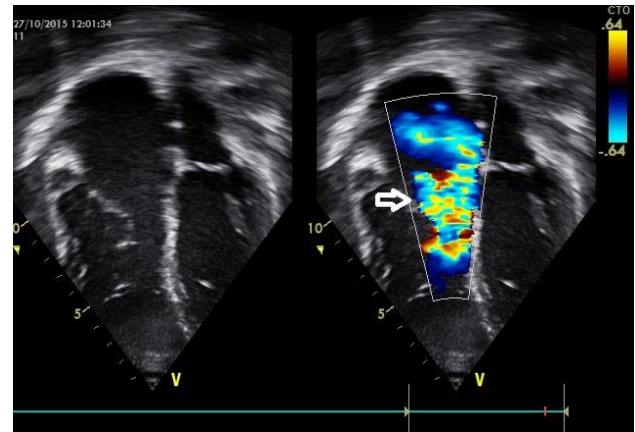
Echocardiography: Four chamber view. Color flow showing moderate TR.
